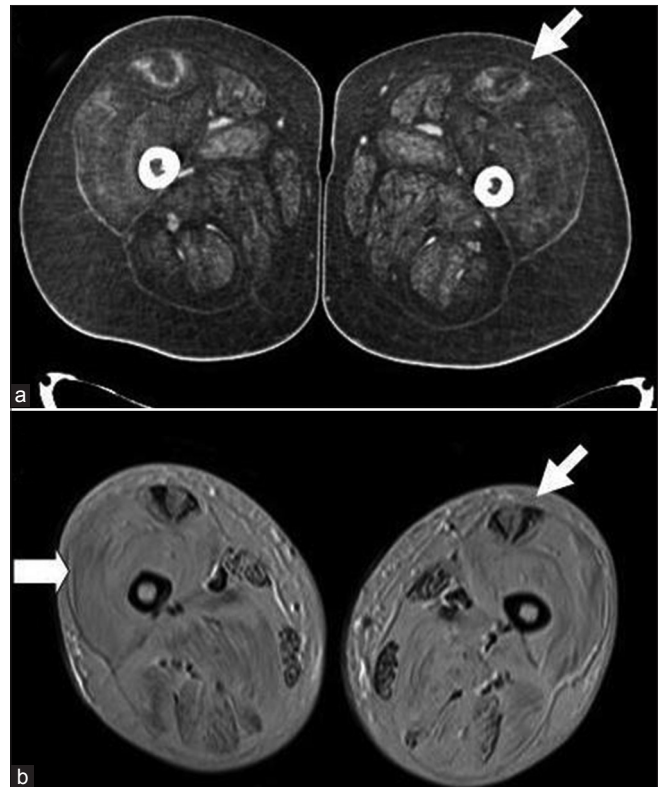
Axial CT scan in the elder son (a) and T2 weighted axial MR image in the father (b). Images show “central shadow” in rectus femoris in both (white arrow head) and predominant quadriceps involvement (thick white arrow)
